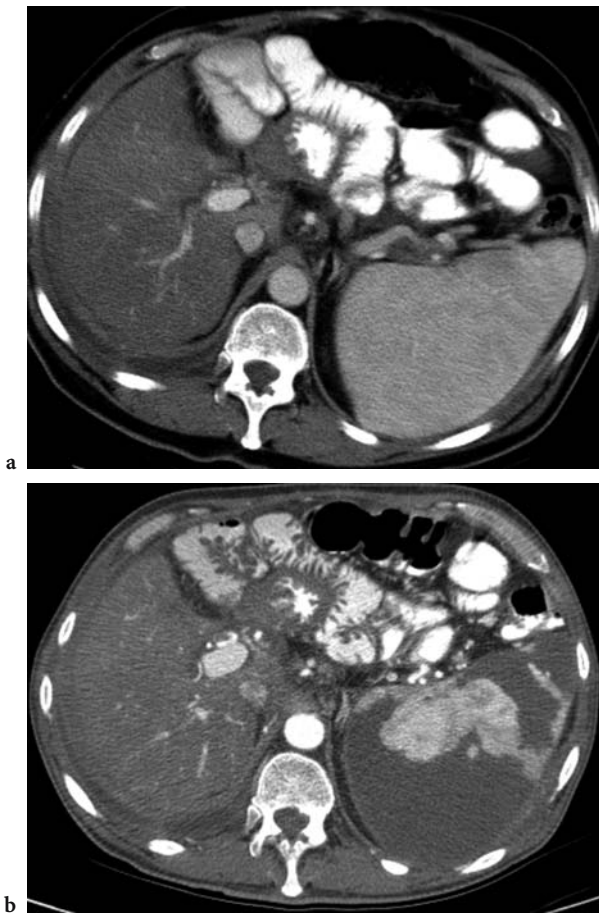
A 48-year-old man with pancreatic cancer presented with persistent neutropenia and thrombocytopenia. Patient was referred for partial splenic embolization (PSE) in an attempt to increase white blood cell and platelet counts prior to additional chemotherapy. Pre-embolization axial CT image of the abdomen (a) shows splenomegaly. CT scan performed 4 months after PSE (b) shows massive necrosis of splenic parenchyma. Within 2 weeks of partial splenic embolization, the platelet count normalized ($379,000/\text{mm}^3$)
